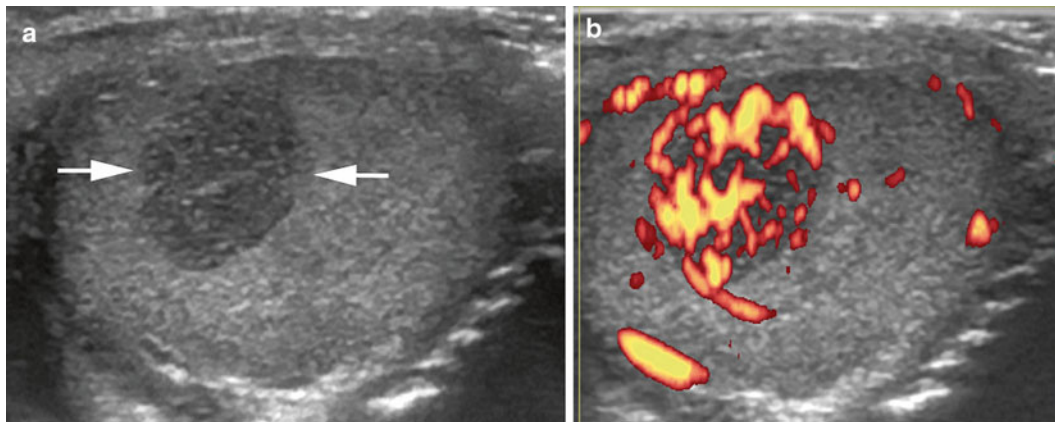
This (a) transverse US image of the testicle reveals a well-defined, small, solid, hypoechoic mass (*arrows*) that on (b) power Doppler imaging appears hypervascular (*orange structures*) in this boy with a testicular Sertoli-Leydig cell tumor
